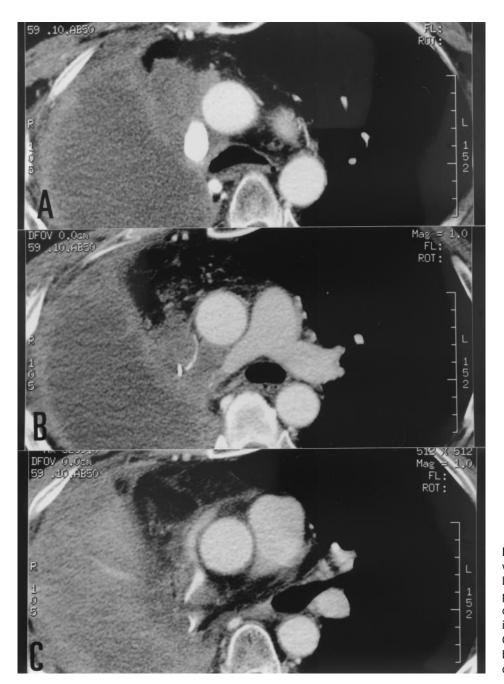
A–C. A 50-year-old man with right pneumonectomy for lung cancer of unknown type, presenting with superior vena cava encasement by tumor invasion seen on 5 mm enhanced CT scans above (A), at (B) and below (C) the pulmonary artery division.
